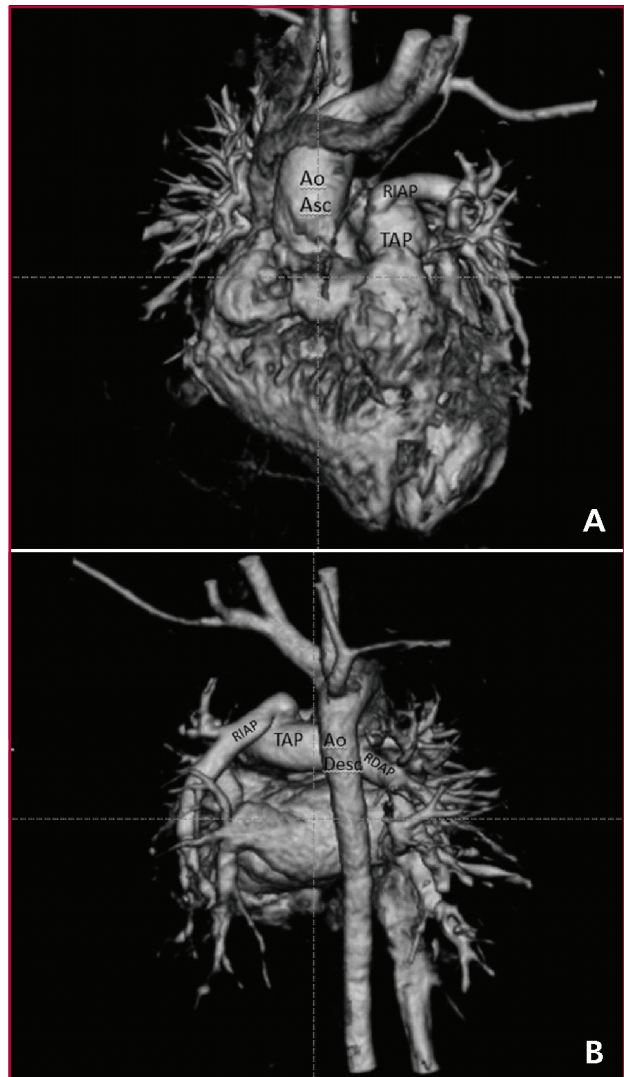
A. Volume reconstruction of computed tomography coronary angiography (oblique view), showing the surgical correction with the left pulmonary artery branching emerging from the pulmonary artery trunk. Ao Asc: Ascending aorta. RIAP: Left pulmonary artery. TAP: Pulmonary artery trunk. B. Volume reconstruction of computed tomography coronary angiography (posterior view), showing the surgical correction with native right pulmonary artery branch emergence and the corrected origin of the left pulmonary artery from the pulmonary artery trunk. As Desc: Descending aorta. RDAP: Right pulmonary artery. RIAP: Left pulmonary artery. TAP: Pulmonary artery trunk
